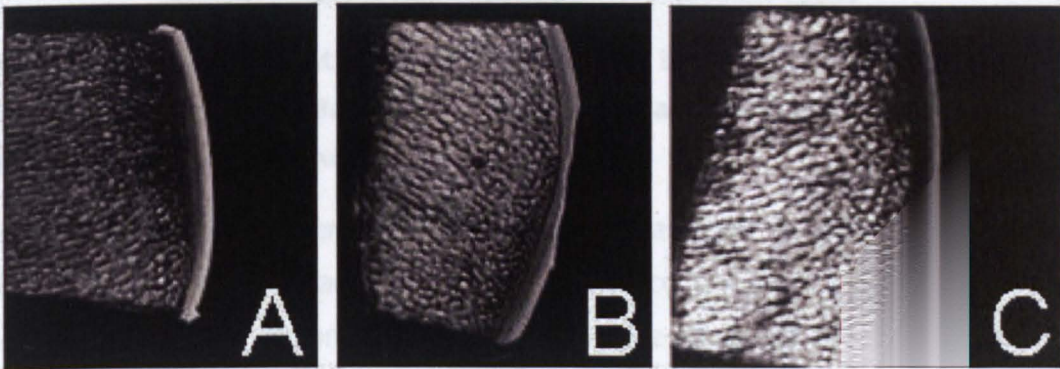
Typical MRI images (a) An unworn sample scanned with a resolution of 0.078 mm/pixel (b) a damaged sample scanned at a resolution of 0.078 mm/pixel and (c) an unworn sample scanned at the higher resolution of 0.02 mm/pixel.
